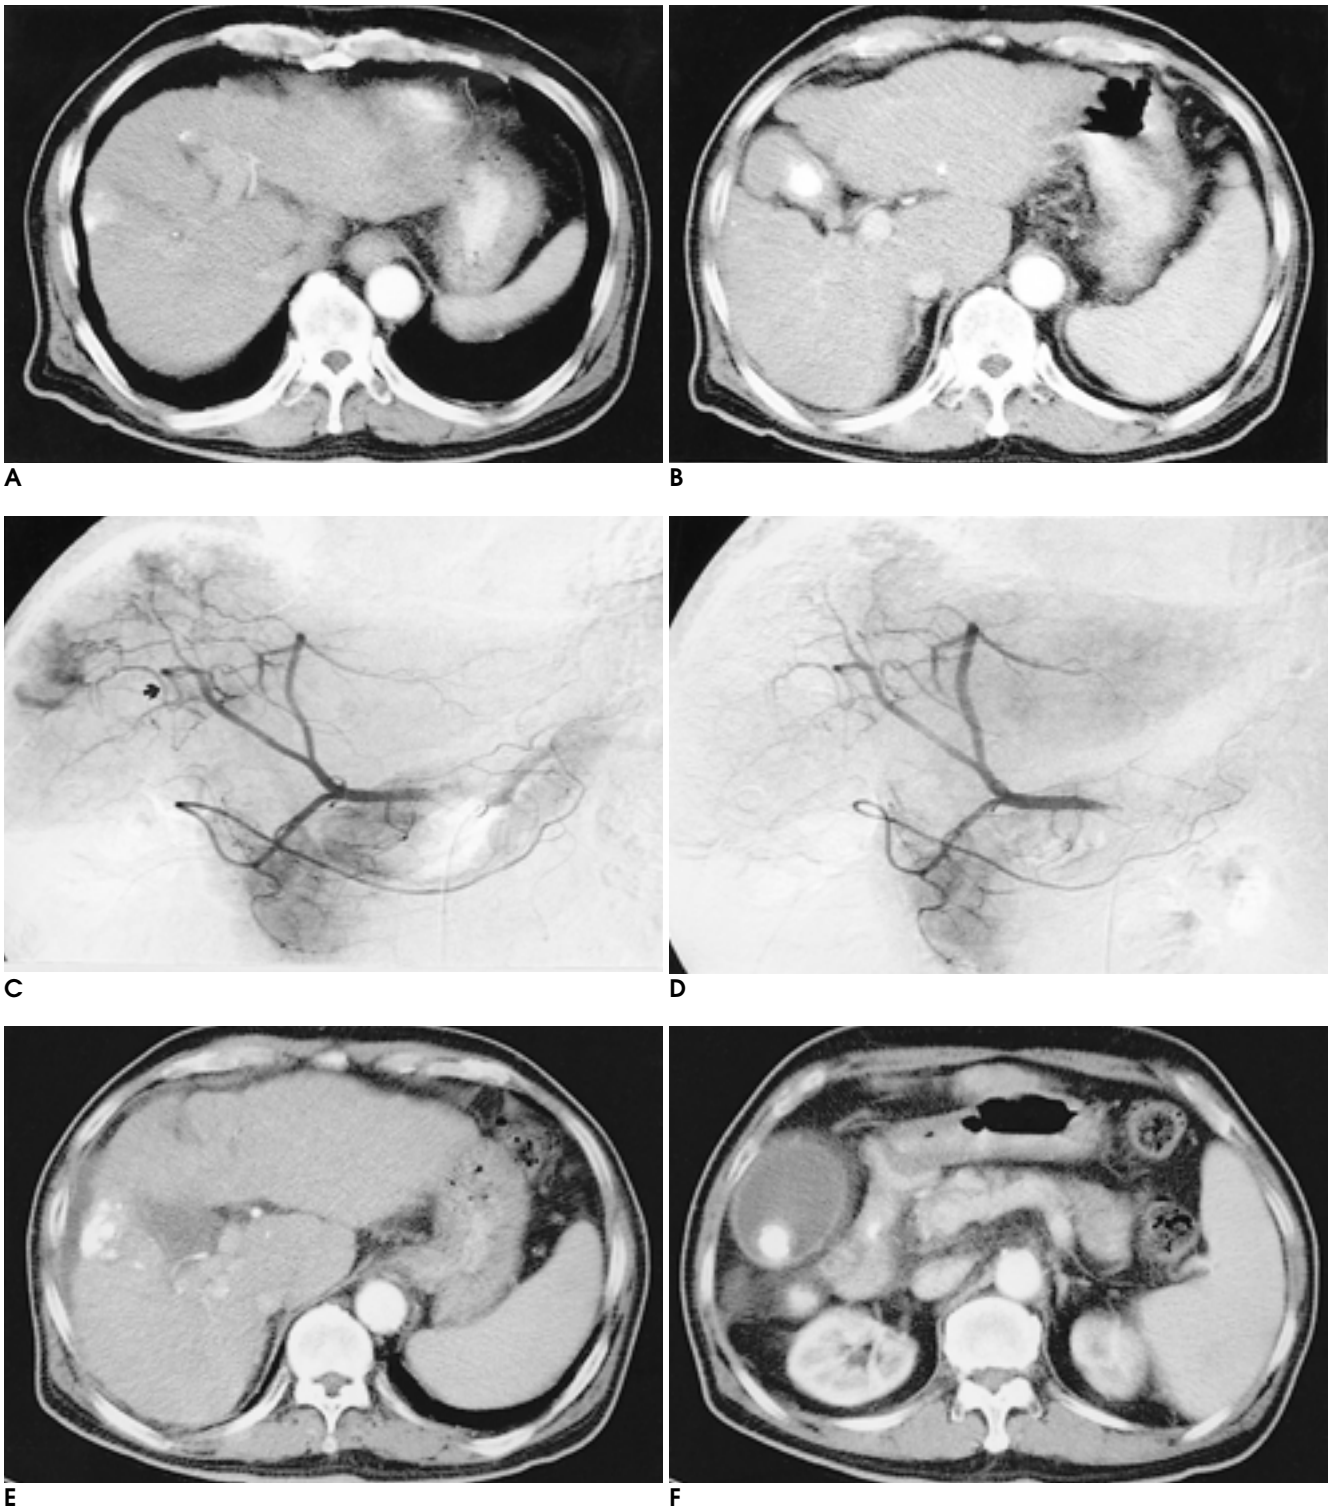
A. Enhanced CT performed prior to TACE reveals a enhancing mass lesion around Lipiodol uptake in segment 5.
